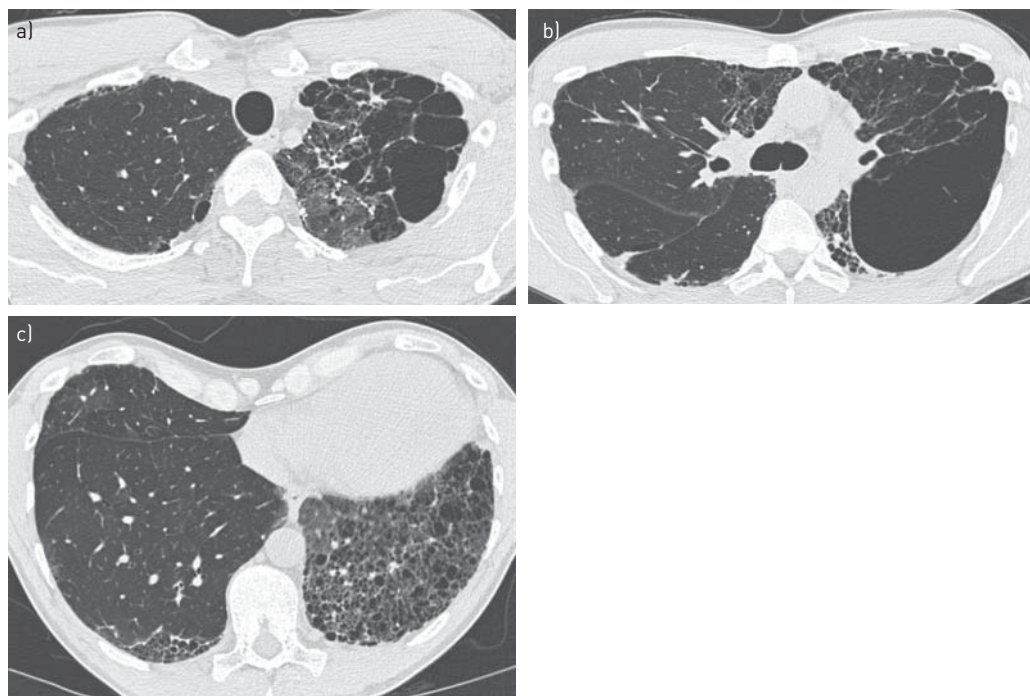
High-resolution computed tomography of the chest showing a, b) left upper lobe predominant emphysema associated with a, c) ground-glass opacities and c) asymmetric honeycomb pattern in the lower zones.
